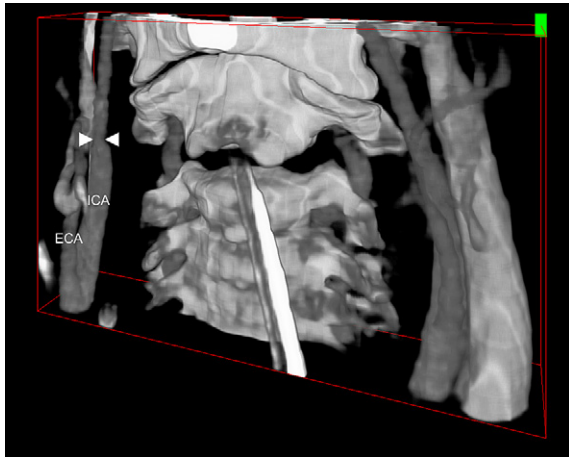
3D image of the CTA dataset demonstrating the calibre difference between the left and right carotid artery. A marked constriction in the right carotid artery is visible (arrows). ICA = internal carotid artery; ECA = external carotid artery.
